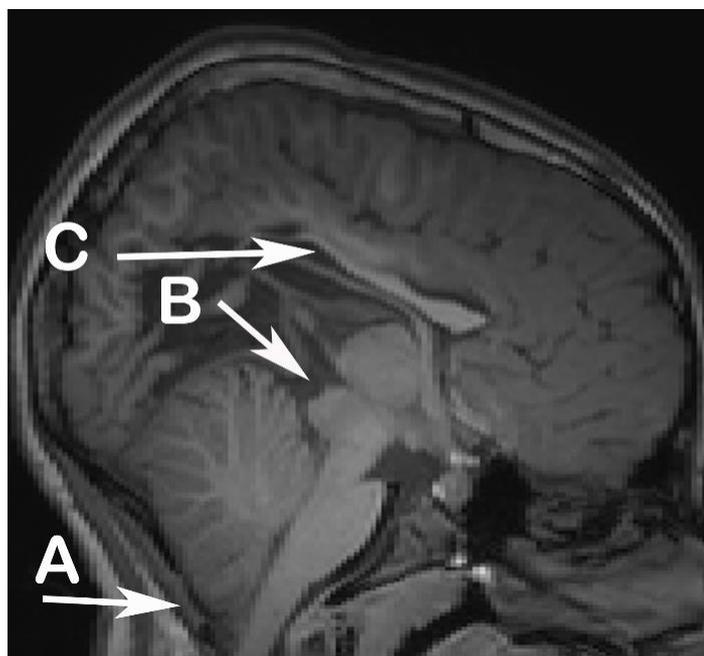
weighted MRI acquired from child with SBM
